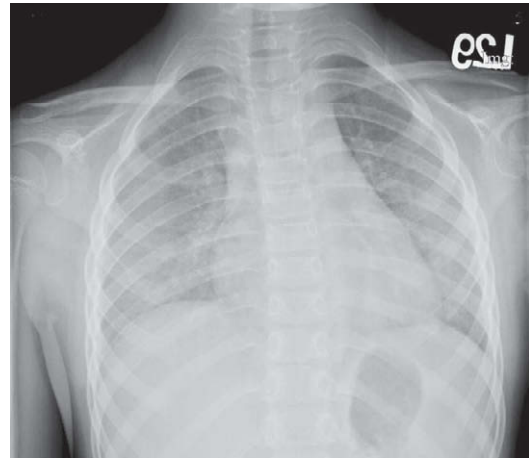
Posterior-anterior view of chest radiography showing bilateral interstitial infiltrates in a 6-year-old girl with right chest pain that could be aggravated by deep breathing. The thoracic vertebrae curved to the right side. The throat swab yielded the growth of coxsackievirus B3.
